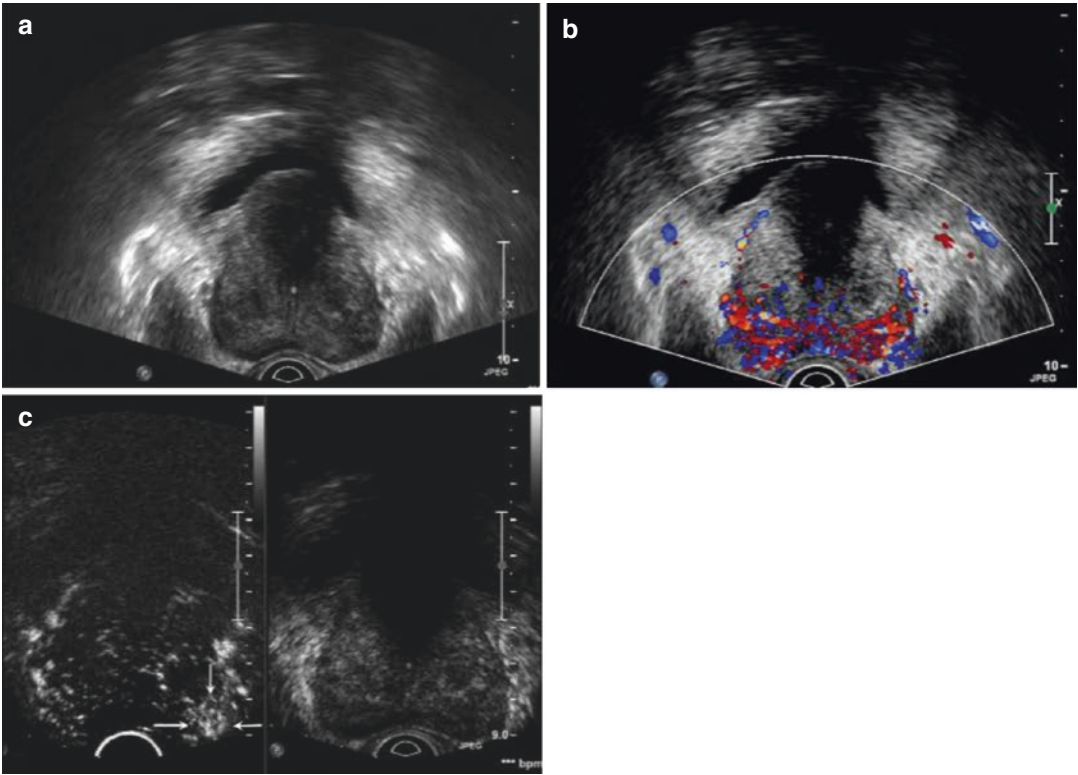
A 70-year-old patient with PSA of 3.3 ng/mL. (a) The image with gray scale does not demonstrate alterations in the basal region of the prostate. (b) The color Doppler image demonstrates a symmetric, significant increasing vascular flow in the basal region of the prostate. (c) The CEUS image evidences a mild enhancement in the lesion in the left basal zone (*arrows*), 19 s after the administration of the contrast medium. The guided biopsy documented PCa Gleason score 3+2
